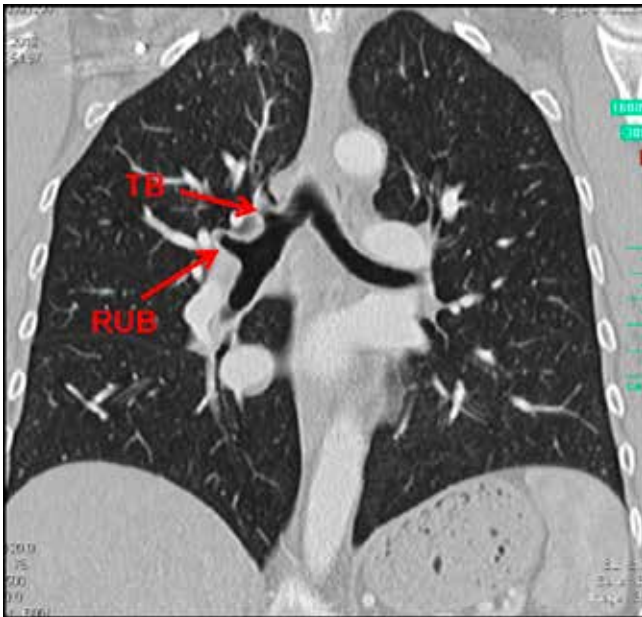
Frontal CT image
